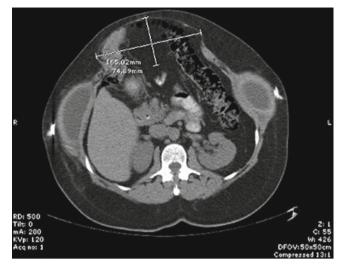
Computed tomographic (CT) scan of the tissue expanders placed between the external and internal oblique muscles
